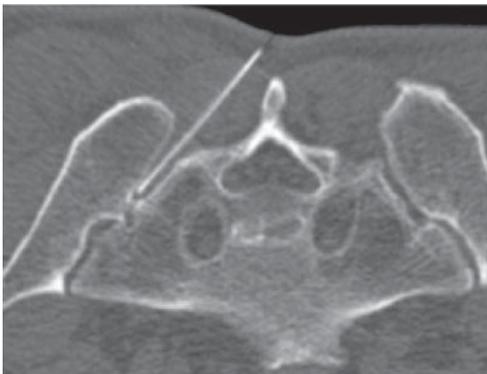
Left sacroiliac joint injection. CT scan of a patient in a prone position at the level of the sacroiliac joint demonstrating a left-sided sacroiliac joint injection.
